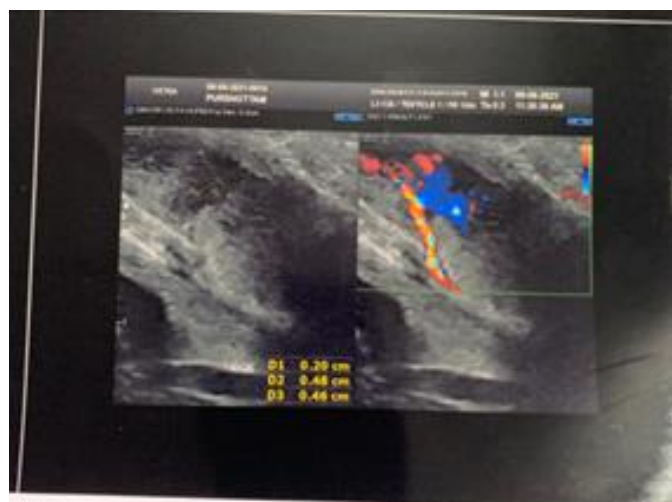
On color Doppler evaluation the lesion shows complete colour filling correlating s/o post traumatic fusiform aneurysm the right CCA, neck of the aneurysm
